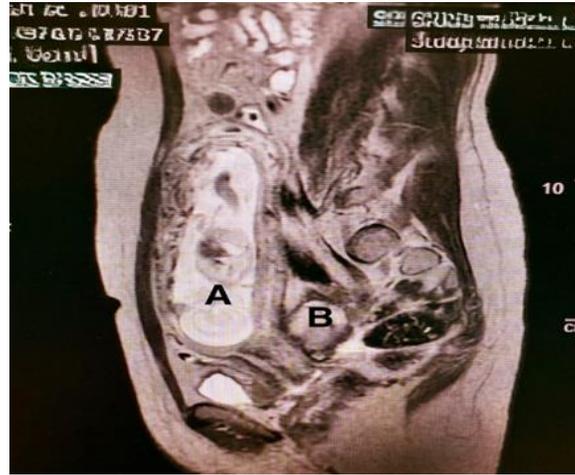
MRI before surgery (A) Intrauterine fetus (B) Extra-uterine fetus
